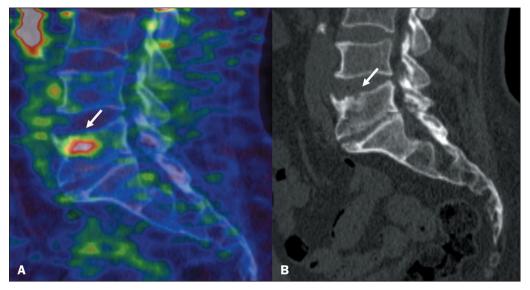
⁶⁸Ga-PSMA PET/CT of a 71-year-old male patient with biochemical recurrence after radical prostatectomy. Image A shows abnormal PSMA uptake (arrow) in vertebral body L5 (SUVmax, 4.3). Sagittal view of a CT scan (B) showing a small nodular lucent lesion with sclerotic margins, consistent with intervertebral disc herniation, on the superior endplate of the lumbar vertebral body (arrow).
